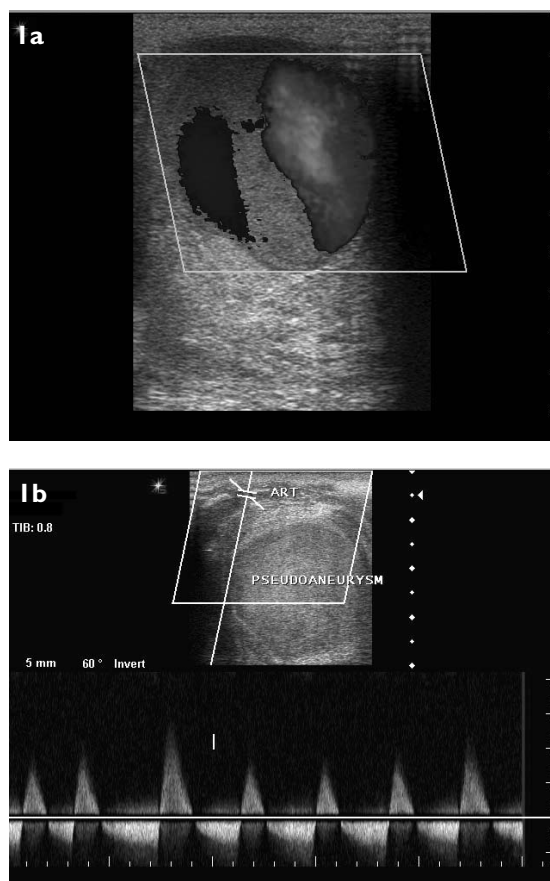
Colour Doppler US image shows (a) a unilocular 60 mm × 40 mm pseudoaneurysm with a small amount of peripheral thrombosis, and (b) a characteristic to-and-fro flow in its neck, which originates from a superficial artery, proven to be a high origin radial artery.
